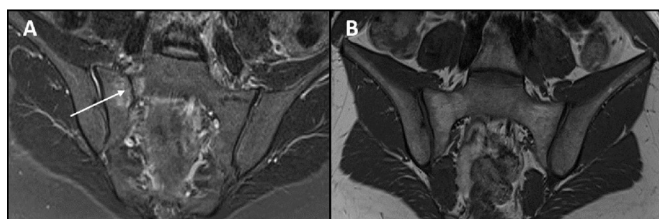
A postpartum sacral fracture on sacroiliac joint MRI of a 28-year-old woman. (A) Shorttau inversion recovery (STIR) sequences of the baseline MRI show a clear fracture of the sacral bone. (B) STIR sequences show a healed sacral fracture after 6 months.
